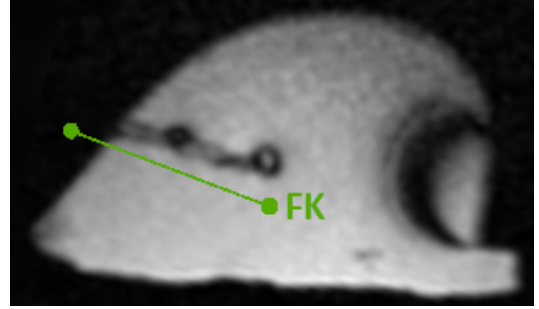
The obtained 2-D slice using continuous MRI imaging from selecting the slice position and orientation in Access-I based on the FK. Showing the needle in-plane and annotated in green is the planned path of the Sunram 7 in ICS.
